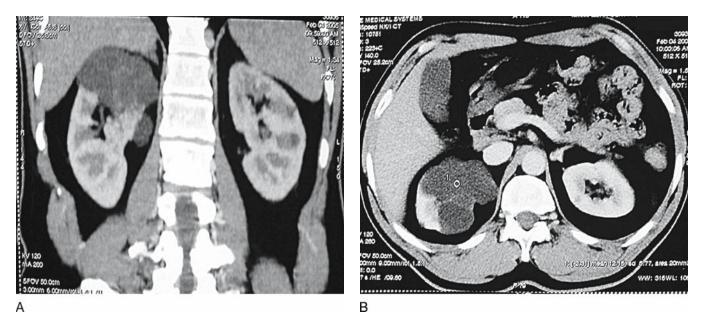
A CT scan of the right kidney shows a multiseptate cyst in its upper pole
